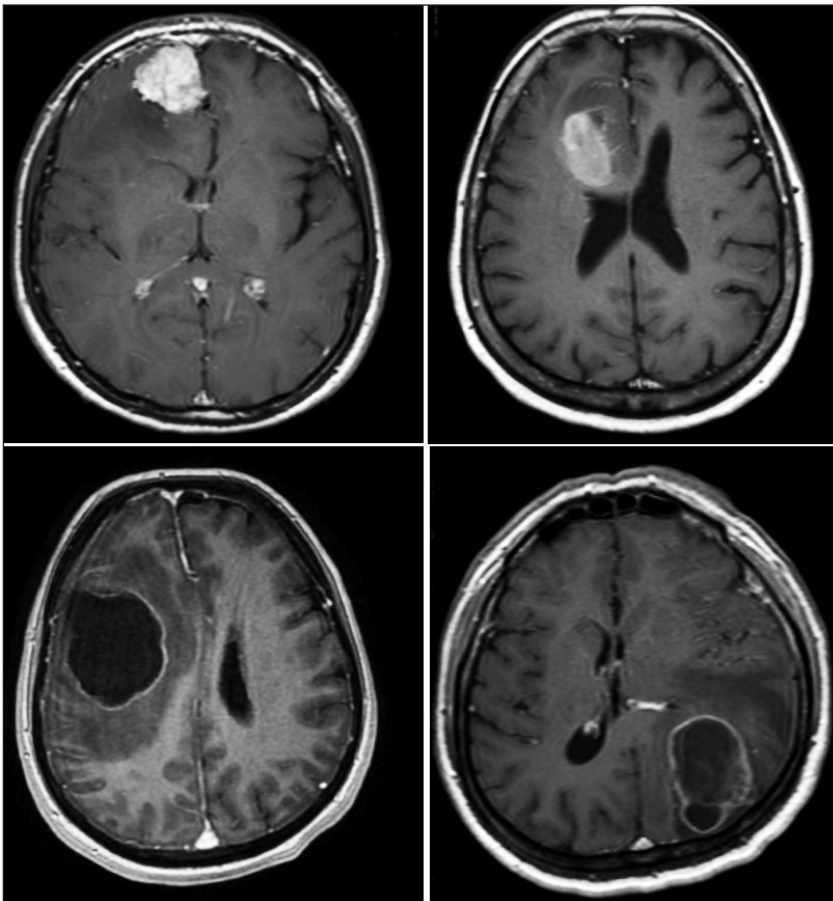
Contrast enhanced T1W axial brain MRI of patients. Images of two patients with contrast enhancement are presented above. Images of two cystic tumors with prominent perilesional edema and midline shift are presented below.
